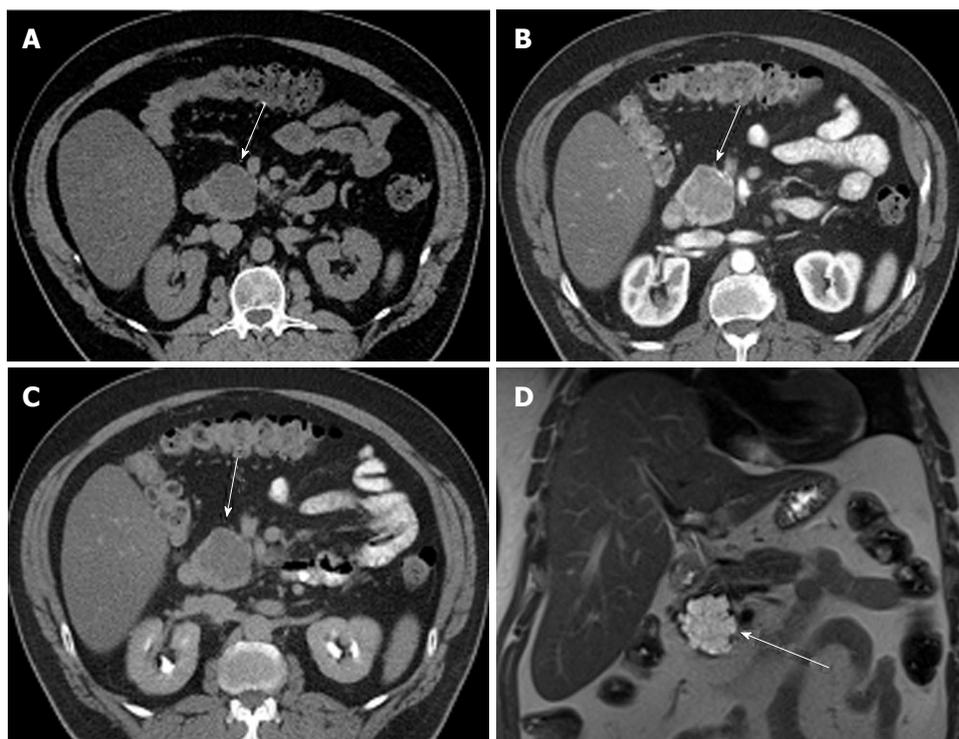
A 65-year-old male with clinically diagnosed typical microcystic serous cystic neoplasm. A: Unenhanced axial computed tomography (CT) shows a low density mass (arrow) relative to the pancreatic head; B: The pancreatic parenchymal phase of a contrast-enhanced CT shows mild patchy tumor enhancement (arrow); C: The equilibrium phase shows the mass to be low density (arrow); D: Coronal T2-weighted single-shot fat saturation-echo magnetic resonance image clearly demonstrate the mass (arrow) consisting of a cluster of microcysts (honeycomb pattern).
